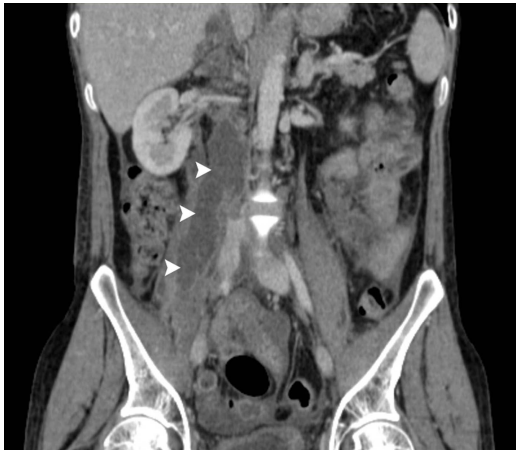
Contrast-enhanced CT of the abdomen in coronal reformation reveals extension of the pancreatic pseudocyst along the length of the right psoas muscle (white arrowheads).
